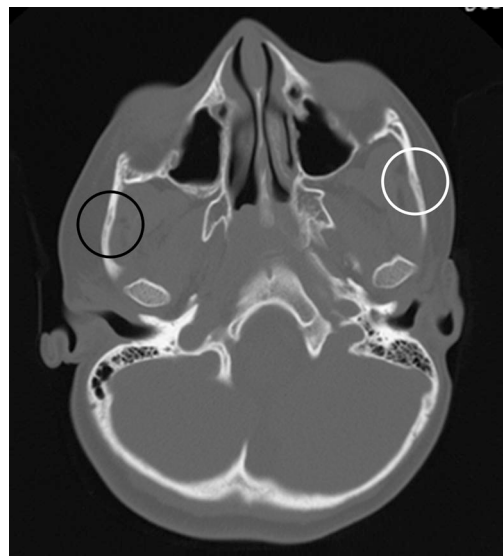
Axial computed tomographic image demonstrating right zygomaticotemporal suture fusion (*black circle*) with shortened and bowed zygomatic process of the temporal bone. The left zygomaticotemporal suture (*white circle*) is patent.
